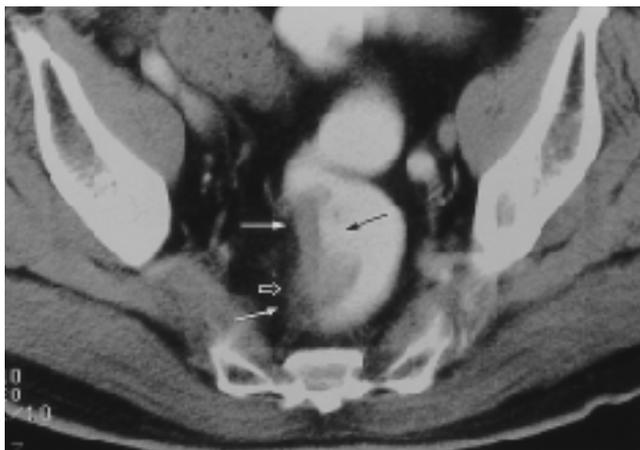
The gastrografin enema CT scan shows ulcerofungating mass of right lateral sigmoid colonic wall(arrow) with subtle soft tissue strands extending into the pericolic fat(open arrow) suggesting T3. Pathologic examination revealed tumor invasion into pericolic fat(T3).
